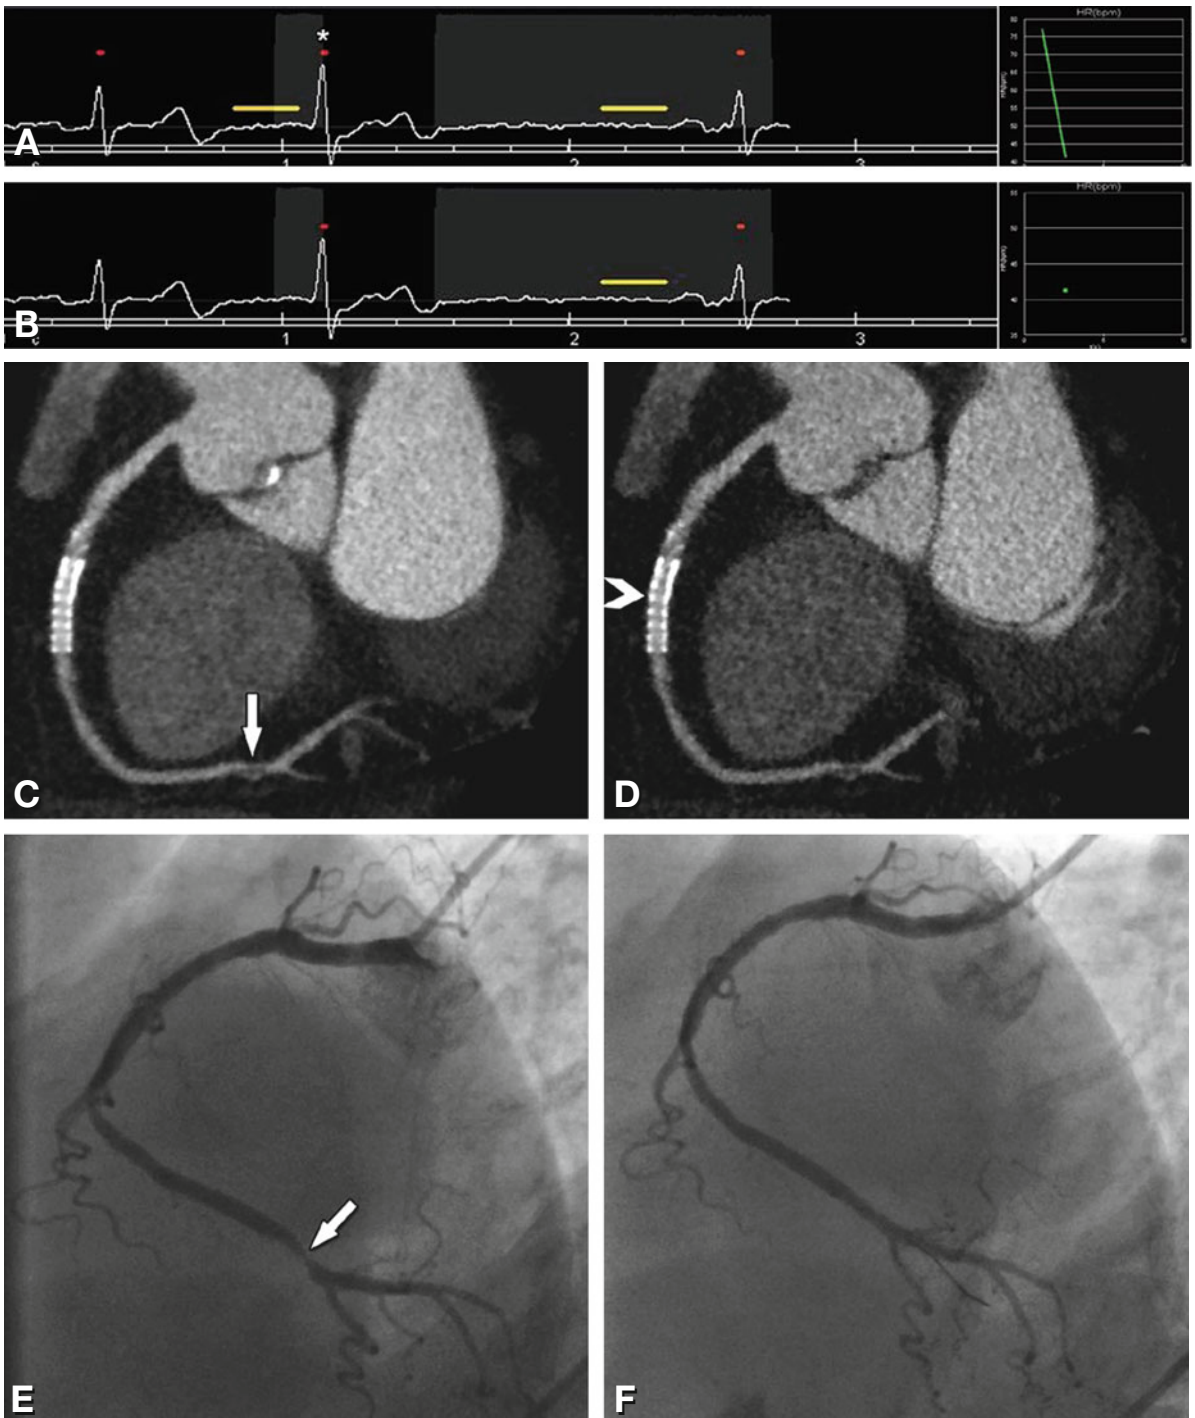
Advantage of volume coronary CTA in arrhythmia. Example of a 66-year-old woman who had a premature atrial contraction during the heartbeat intended for volumetric scanning (*asterisk* in Panel A). Scanning was immediately stopped when the arrhythmia occurred and was continued during the subsequent beat with a safety window (Panel A). These two beats had a rate of 77 and 41 beats per min (Panels A and B). Only the second, nonarrhythmic beat was used for reconstruction of images (Panel B). Reconstructions with a soft filter showed a significant (70% diameter) stenosis of segment 3 of the right coronary artery (RCA, *arrow* in Panel B), whereas significant in-stent restenosis of the 3.0-mm mid-RCA stent was excluded in reconstructions with a stent filter (Panel D). Conventional coronary angiography confirmed the significant distal RCA stenosis (*arrow* in Panel E), which was treated during the same interventional session (Panel F)
